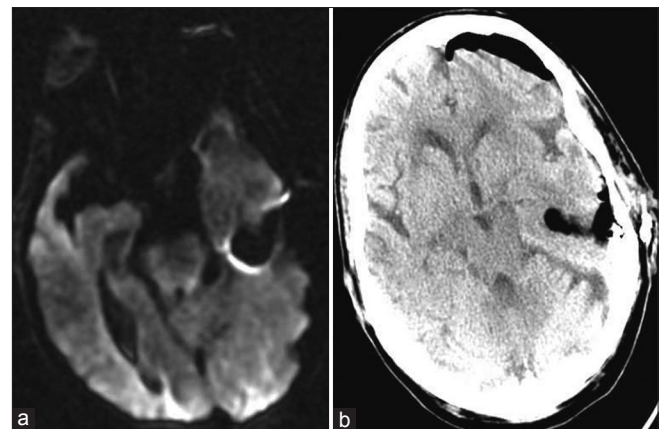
Postoperative (a) magnetic resonance imaging brain (axial image). (b) Computed tomography scan of the brain without contrast showing gross total excision of the lesion
